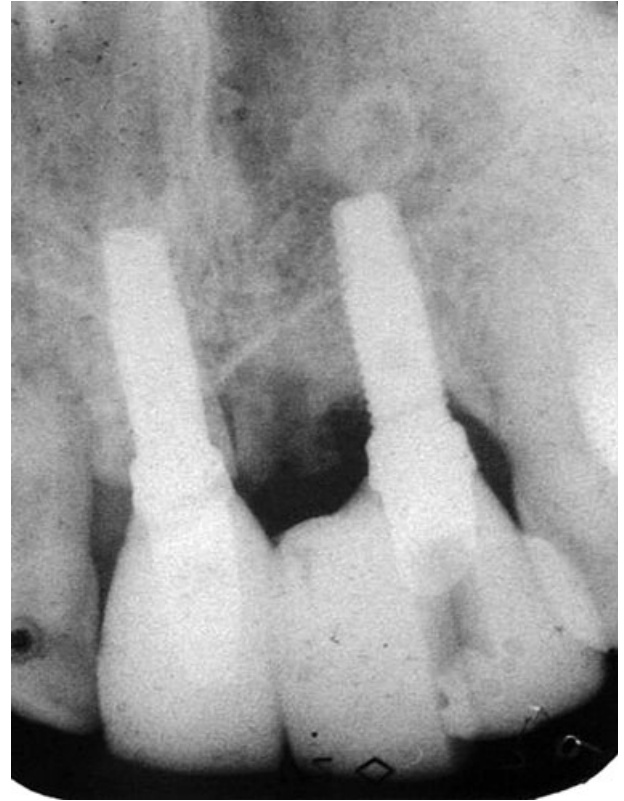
Final periapical radiograph of the temporary prosthetic rehabilitation.
